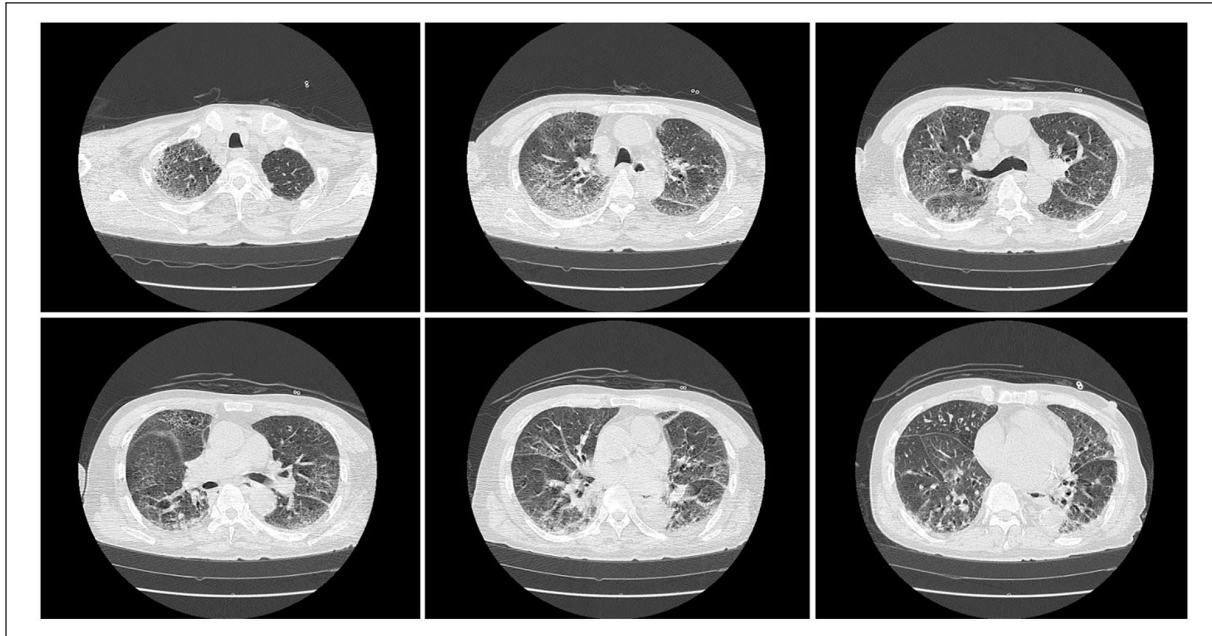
Chest computed tomography performed in the former hospital reveals diffuse bilateral ground-glass opacities.
